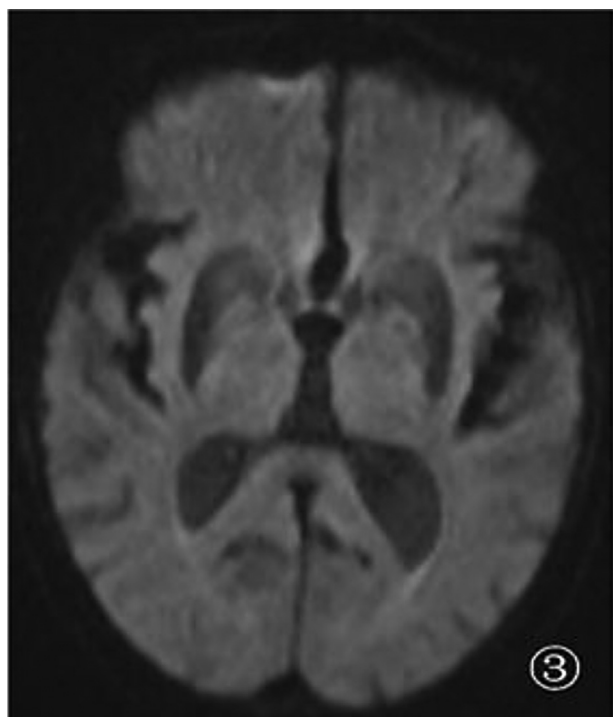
DWI: Negative changes were found on DWI and ADC images.
